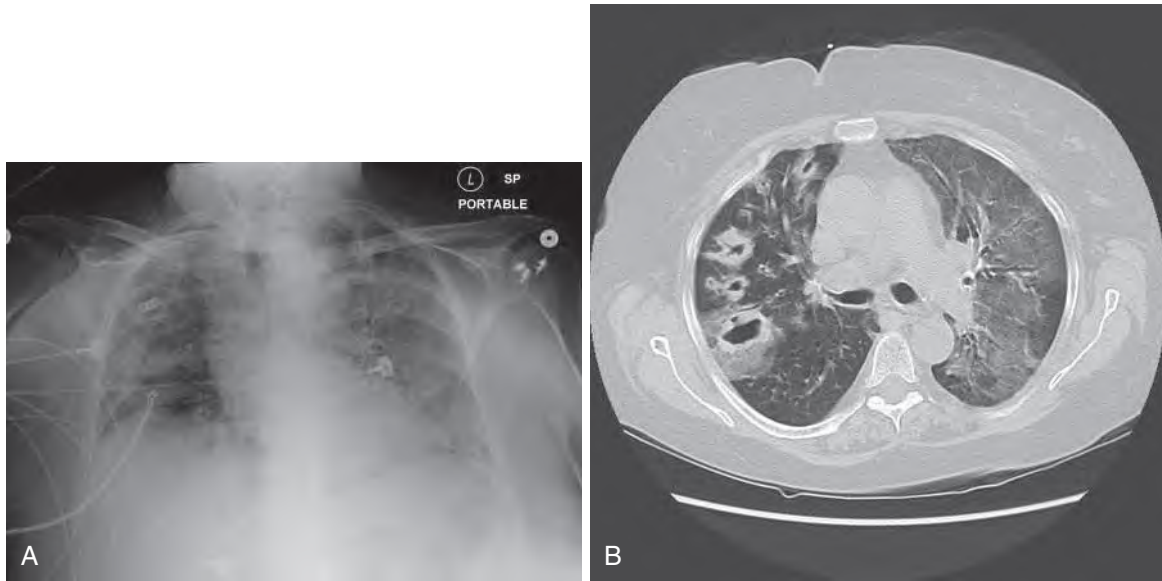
(A) A 68-year-old former nurse presented with fever and cough productive of yellowish, blood-tinged sputum for 2 weeks. She is a smoker with chronic obstructive pulmonary disease and asthma. She received intermittent glucocorticosteroids for asthma exacerbations. Methicillin-susceptible *Staphylococcus aureus* (MSSA) was recovered from sputum, and a bronchoalveolar lavage revealed 4+ gram-positive cocci in clusters among sheets of neutrophils. Cultures were positive for MSSA. (B) A computed tomography scan from the same patient reveals bilateral alveolar infiltrates with well-circumscribed cavitary lesions consistent with the diagnosis of community-acquired MSSA pneumonia.
